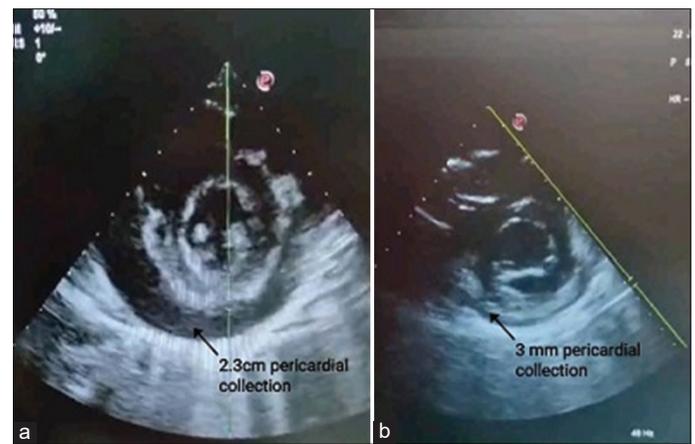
Parasternal short axis view showing (a) pre paracardiocentesis; (b) post paracardiocentesis
